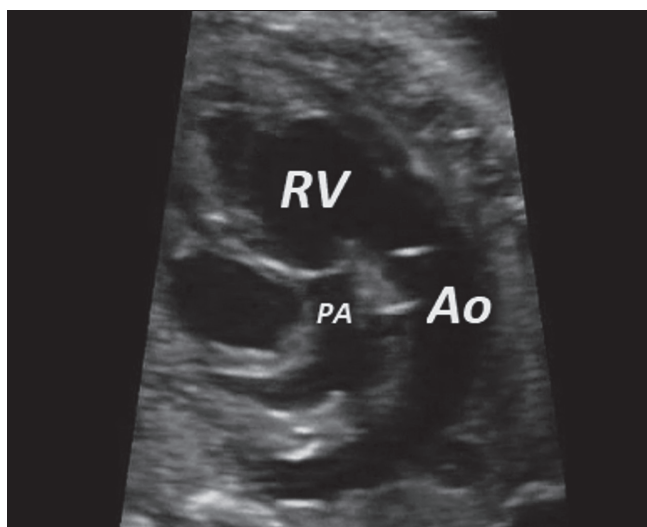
The fetal cardiac ultrasound in the sagittal view of the great arteries shows a small PA, representing pulmonary stenosis, and a dominant connection of the Ao and the pulmonary artery to the RV, demonstrating DORV.
